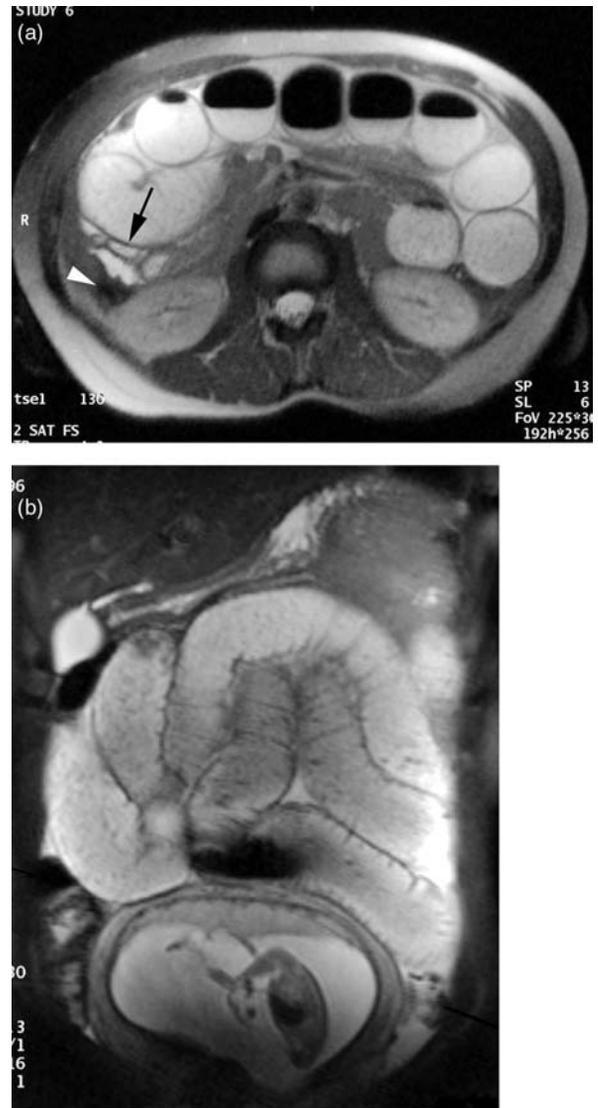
Appendicitis with phlegmon in patient with severe right lower quadrant pain (27 weeks pregnant). Sonogram (not shown) demonstrated a right lower quadrant phlegmon. Axial (a) and coronal (b) T<sub>2</sub>-weighted SSFSE images show a heterogeneous moderately hyperintense mass in the right lower quadrant consistent with an inflammatory phlegmon with a markedly enlarged appendix measuring 2 cm in diameter (arrowheads). The patient was treated with intravenous antibiotics. (c) After 5 weeks, sagittal T<sub>2</sub>-weighted image demonstrates slight decrease in size of the appendix. The patient was delivered at 33 weeks, with appendectomy performed at the time of cesarean section, the latter confirming appendicitis. [(a) from Eyvazzadeh et al. (65)]
